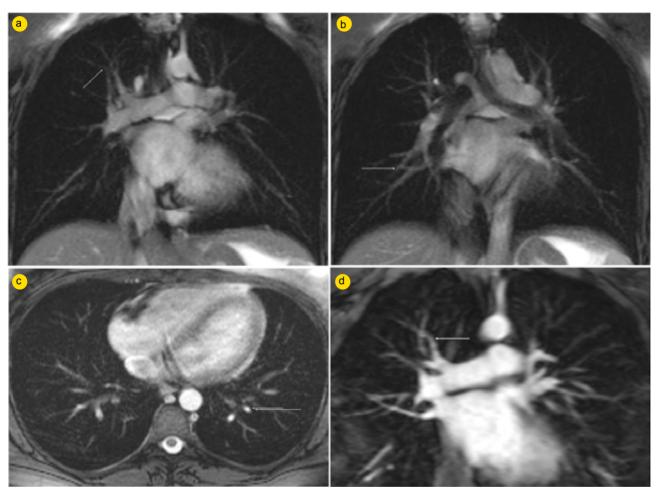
True Fast Imaging Steady-state free precession (TrueFISP) images in the coronal (a,b) and in the axial (c) planes of a 28 year/old pregnant woman and T1-weighted post-gadolinium three dimensional gradient-eco (3D-GRE) image in the coronal plane (d) of a 32 year/old woman that underwent MRI for suspected pulmonary embolism. Good image quality, signal intensity and definition for confident diagnosis were found at central, lobar and most segmental (arrow, c) pulmonary vessel parts both using TrueFISP and 3D-GRE in these two different patients.
